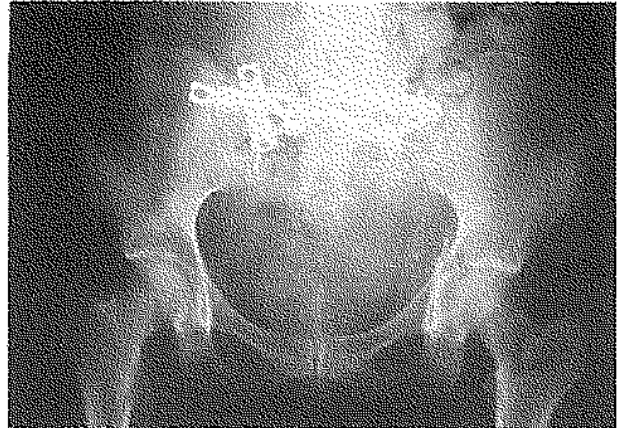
Radiograph of the affected area after reconstruction.
